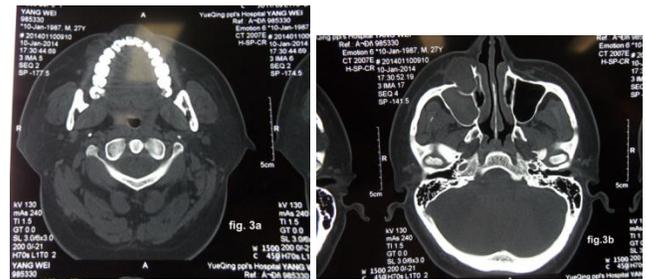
CT fig 3a- axial, fig 3b- axial and fig 3c- coronal view reveals cystic cavity involving right maxillary sinus crossing mid line associated with supernumerary teeth.
